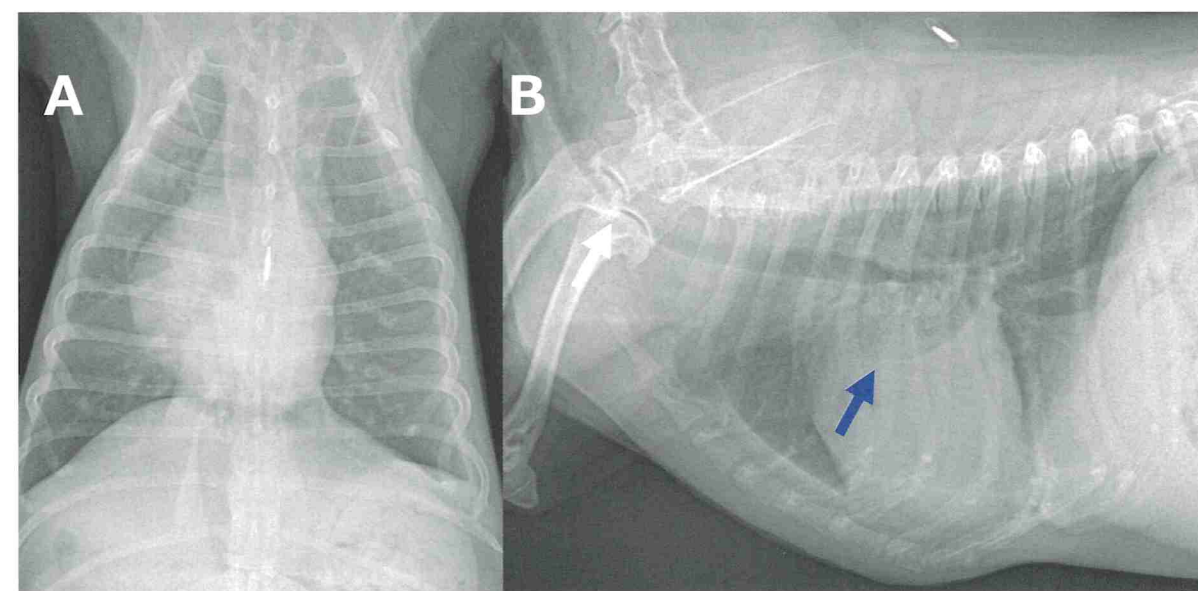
1B Ventrodorsal (A) and lateral (B) thoracic radiographs of a maltese at initial presentation (Day 1). Note the marked tracheal collapse from the cervical to pectoral region during the phase of inspiration and exhalation (white arrow). The right middle lung lobe had decreased pneumatisation (blue arrow), and there was an oblique fissure of the lung.
